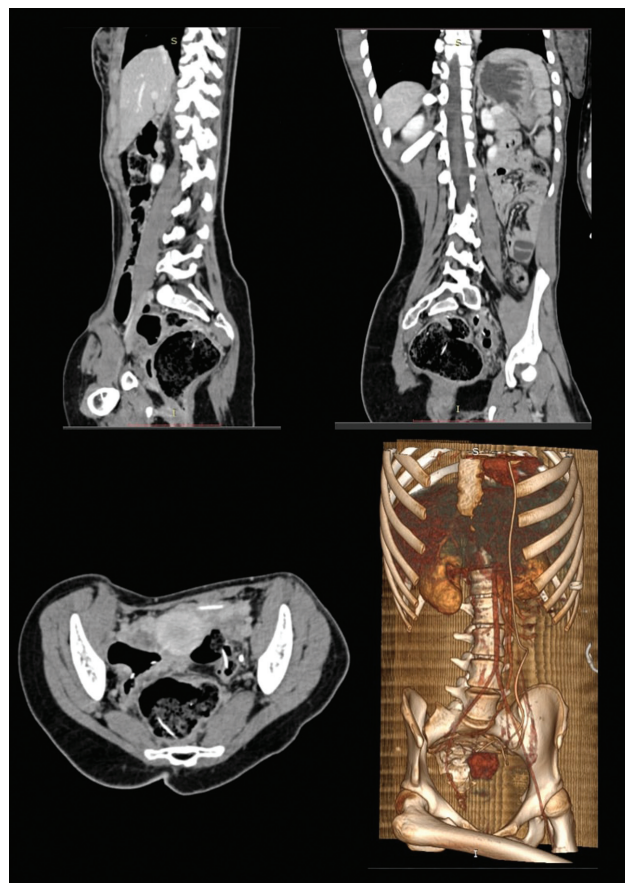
Abdominal computed tomography scan showing the peritoneal catheter perforating the descending colon.
